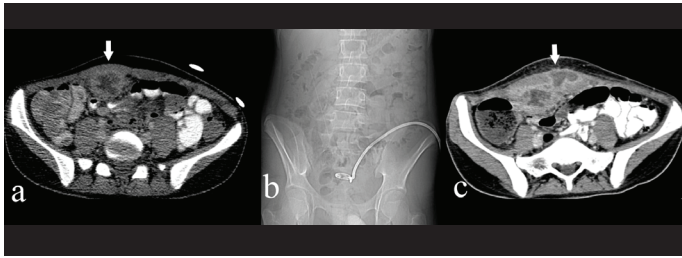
Abscess formation (arrow) on pre-interventional CT (a), the drainage catheter on X-ray during scopic control (b) and the progression in abscess volume (arrow) on post-interventional CT (c) 17 days after percutaneous drainage in 18-year-old man with perforated appendicitis.
